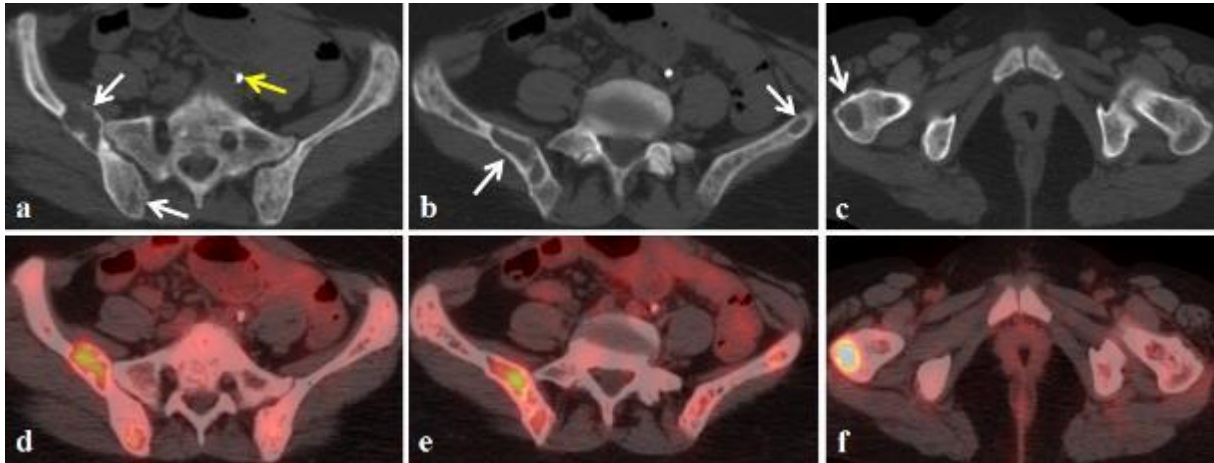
a, b and c NECT shows multiple osteolytic lesions of the bones of the pelvis and the right femur, mostly medullary, thinning the cortex of the right iliac bone (a). We also noted a left JJ stent, indicated by the yellow arrow. d, e and f: Axial PET-scan sections superimposed on the abnormalities noted on conventional imaging, showing the uptake of 18-FDG by the bone lesions.
